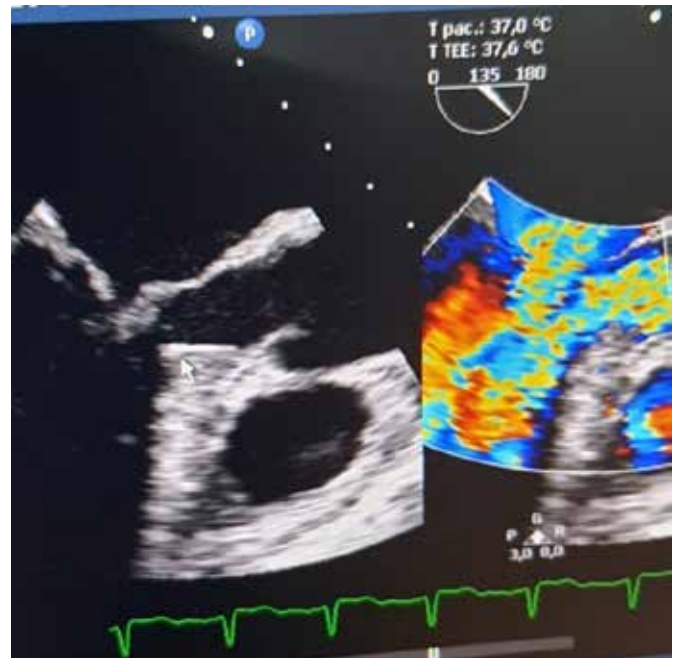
Transesophageal echocardiogram image demonstrating turbulent and disorganized flow due to LVOT narrowing.
